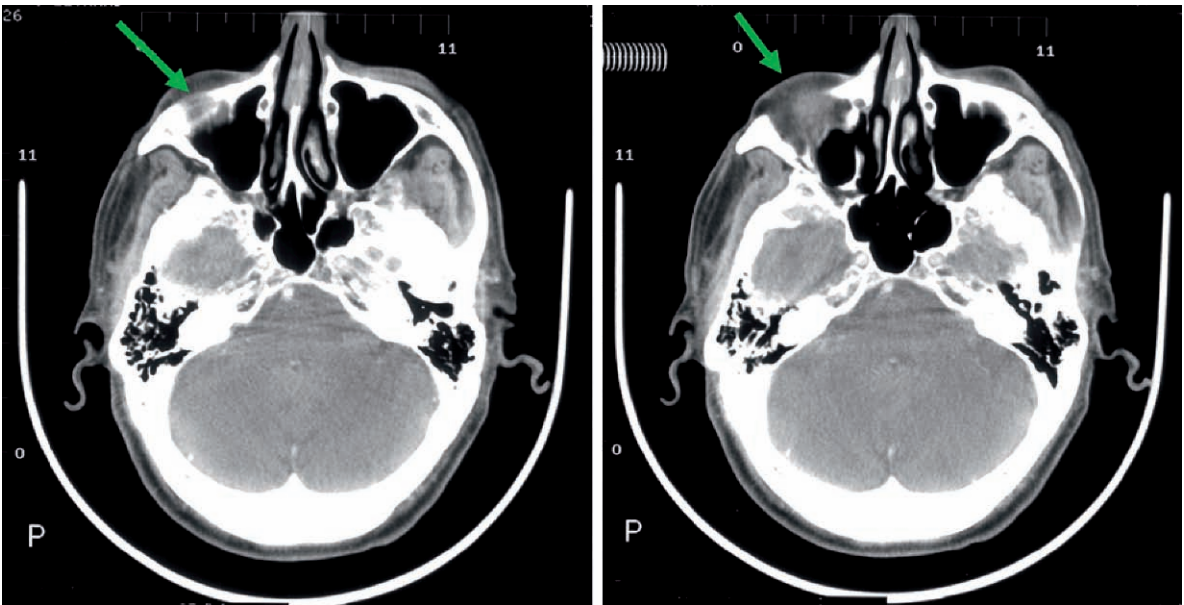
Axial multislice computed tomographic view of same case as that shown in Fig. 11.14. The carcinoma has caused erosion of the anterior sinus wall and soft tissue proliferation is now apparent. The panoramic radiograph was the initial examination; however, computed tomography was needed to better define the lesion and represents the appropriate next step in imaging in this case
